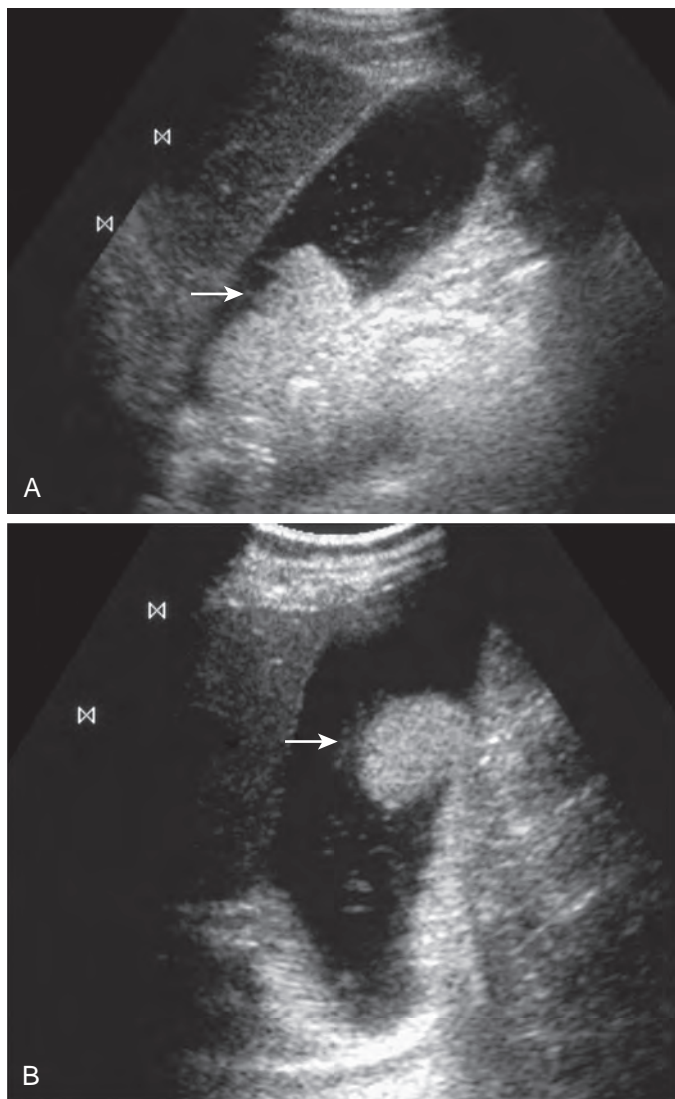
Aggregate of sludge on ultrasound. A. Sagittal ultrasound image of the gallbladder demonstrates an echogenic nonshadowing abnormality located dependently within the gallbladder lumen (arrow). B. When the patient is imaged in the upright position, this abnormality changes location and configuration (arrow), confirming aggregate of sludge rather than soft tissue mass.
